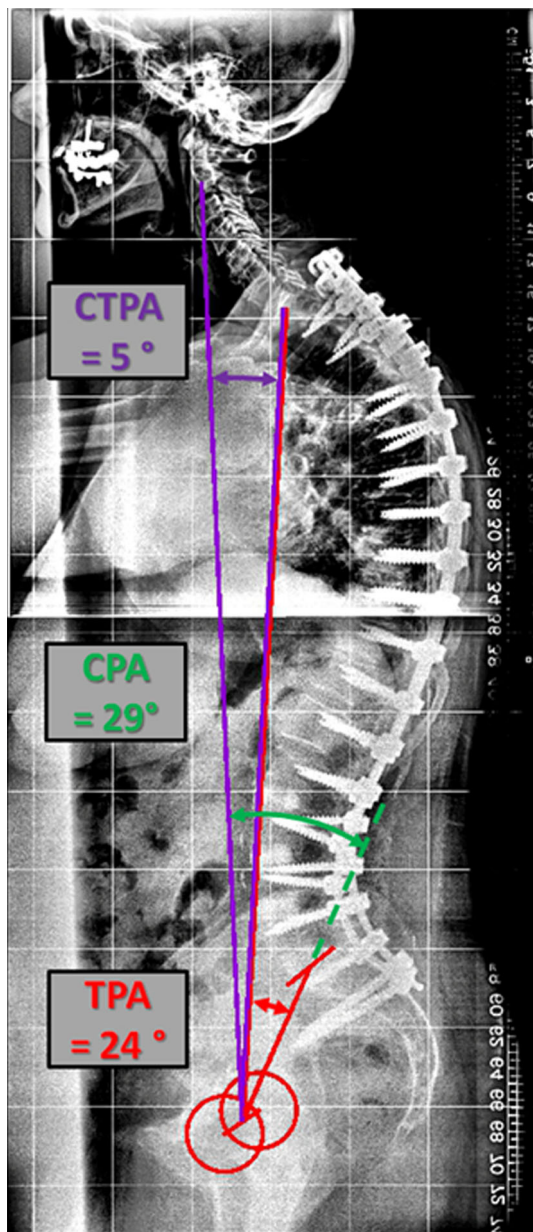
Global radiographic parameters: CTPA, which is the angle of a line from center of C2 to femoral heads (FH) and a line from FH to center of T1, is a global angular measure of cervical sagittal balance and a correlate of the C2–C7 plumbline. TPA is a global sagittal alignment measure that correlates with C7 SVA and is measured by the angle of a line from the center of T1 to the FH and a line from the FH to the center of the S1 endplate. CPA (C2 pelvic angle) is the angle of a line from C2 centroid to the femoral heads (FH) and a line from the FH to the middle of the S1 endplate. CTPA is the result of subtracting the TPA from the CPA ($CTPA = CPA - TPA$)
